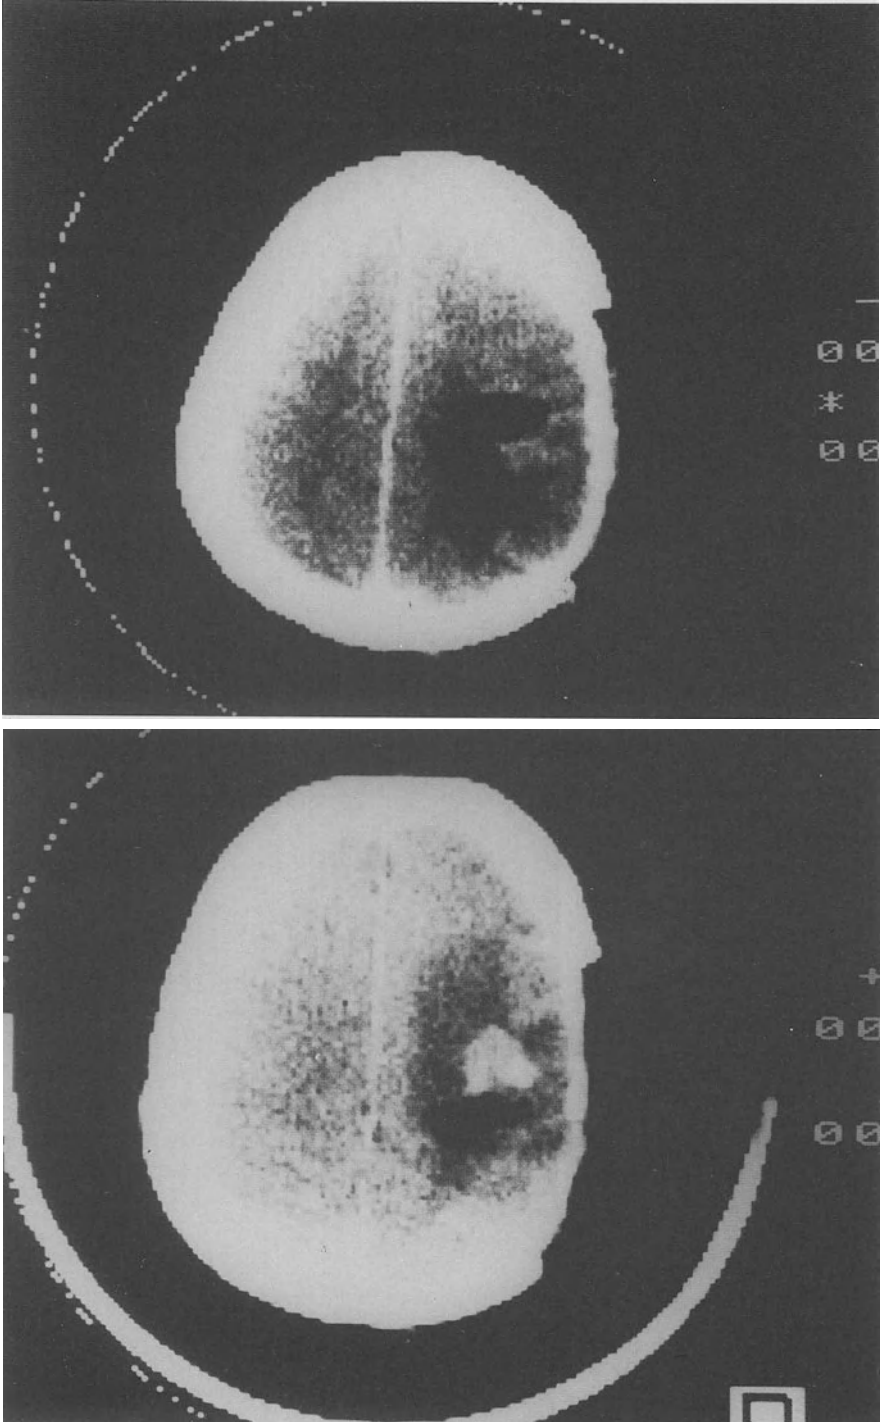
a Postoperative CT scan of a right parietal glioblastoma; b 18 months after radiotherapy, radionecrosis mimicking a recurrence
